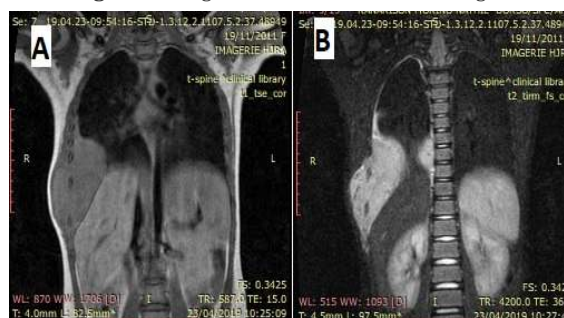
MRI revealed invasion of the anterior spinal cord and the intramedullary tumoral extension is located at T6 and T9 level.
